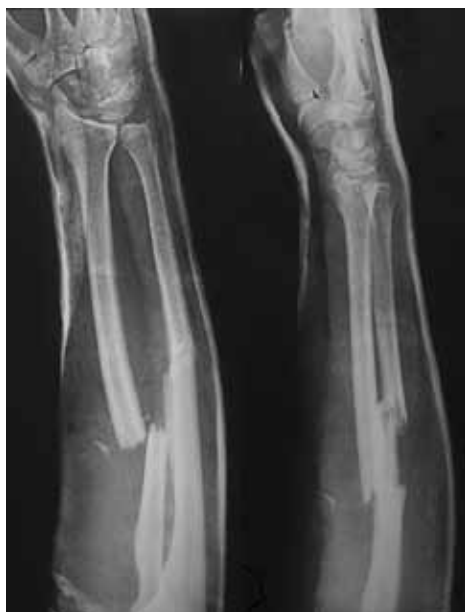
Patient A., 16 y.o. X-ray of the forearm bones – comminuted diaphyseal oblique-transverse spiral both-bone fracture
